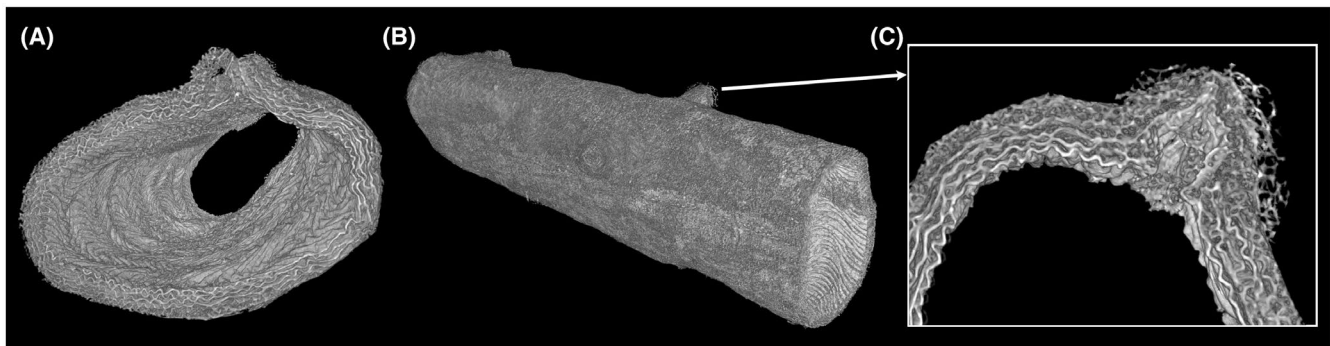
3D reconstruction of C57Bl6J aorta elastic structures. A, Surface render of X-ray tomogram (total length 1.78 mm). The internal surface is rippled, with a periodicity of 220 μm , due to the lack of internal pressure. B, Global view of the 1.78 mm aortic segment. A secondary artery junction is zoomed on figure (C) where a cross-sectional view shows the elastic tissue local reorganization
